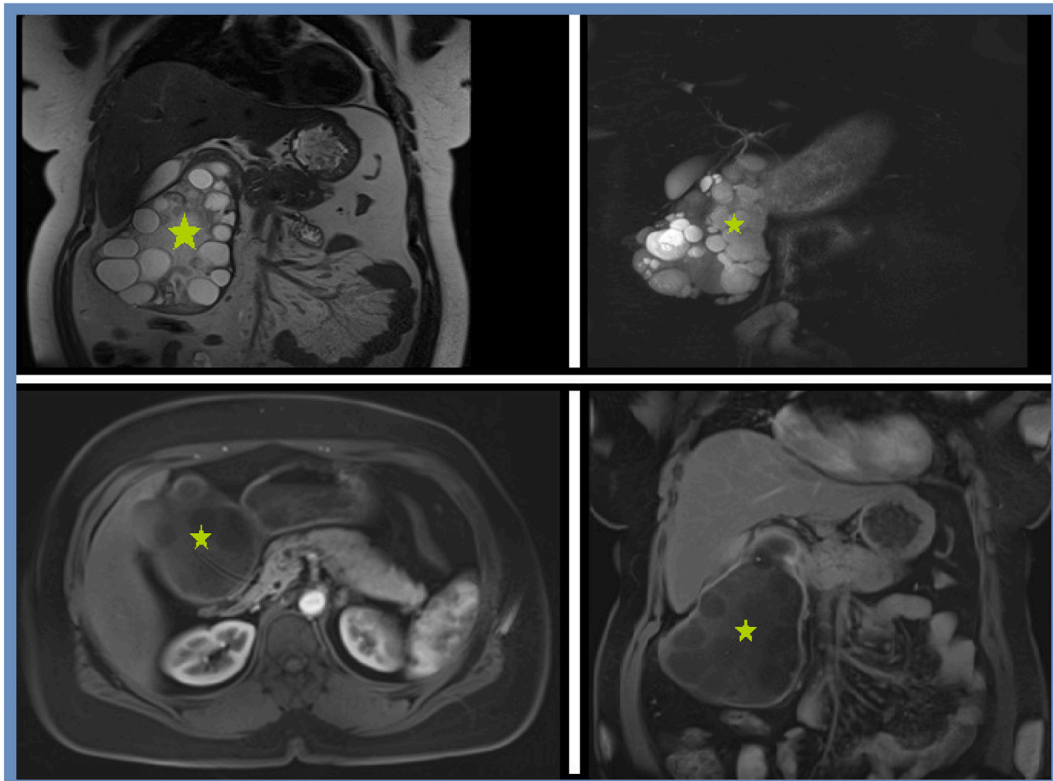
Different MRI views showing a multiseptal hydatid cyst without fistulization.
